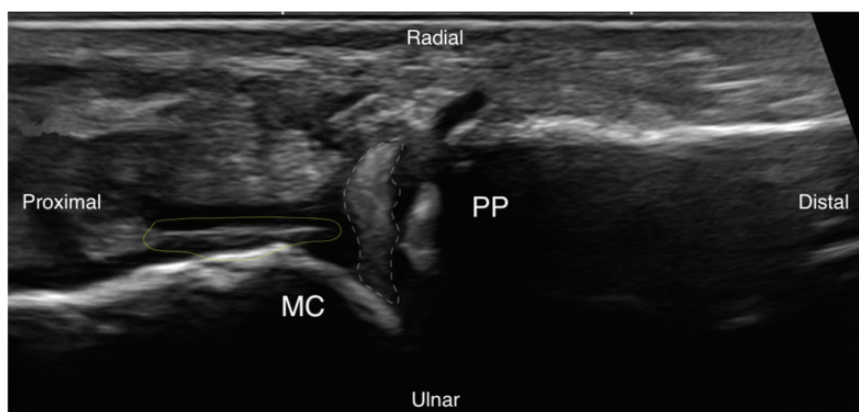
Long-axis sonogram of the MCPJ of the index finger (radial aspect). The entrapped limb of the radial collateral ligament (dotted white outline) is seen inside the MCPJ between the metacarpal head and base of the proximal phalanx. There is also evidence of articular cartilage injury with a small piece of cartilage (solid yellow outline) lying just radial to the metacarpal head.
